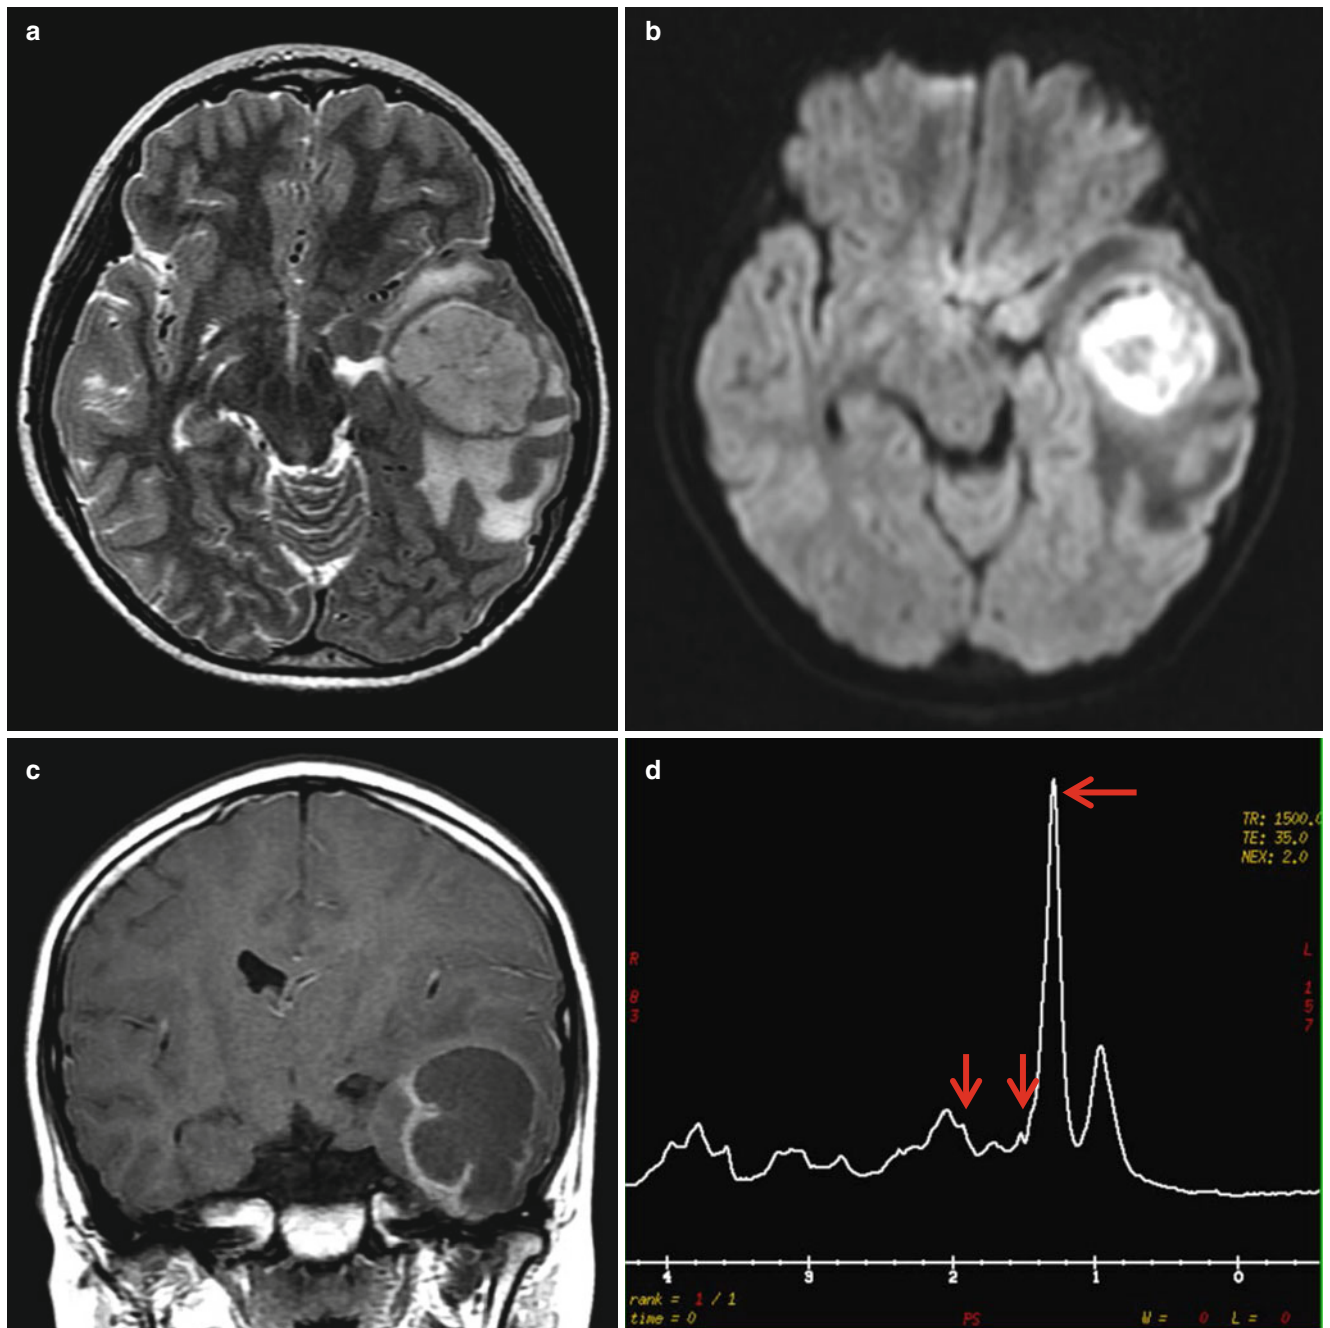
Brain abscess in an 11-year-old boy with fever and headache. (a) T2-weighted image shows high-signal-intensity lesion with a surrounding low signal rim in the temporal lobe. (b) Diffusion image shows restricted diffusion of the content. (c) Postcontrast image shows
